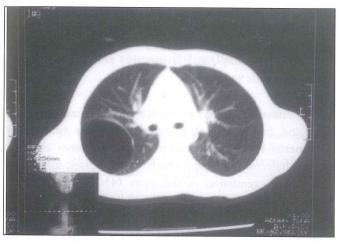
Chest CT scan demonstrating large pneumatocele in the right upper lobe.
